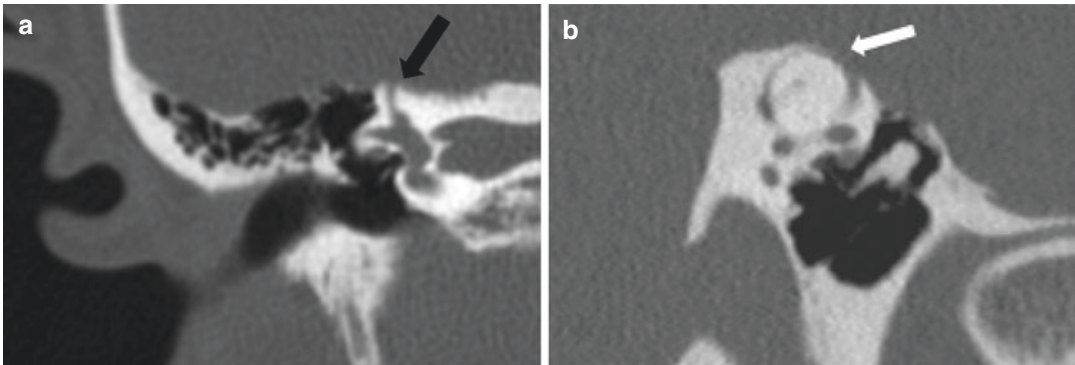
(a) CT scan of superior semicircular canal dehiscence (*black arrowhead*), (b) CT scan of superior semicircular canal dehiscence (*white arrowhead*) in Pöschl plane
